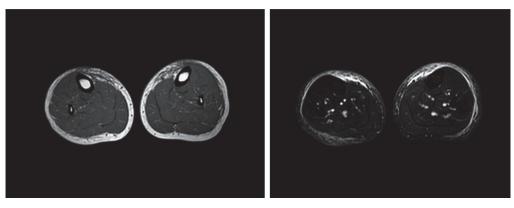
Magnetic response imaging (MRI) of lower legs. Left: T1-weight image on MRI. Right: Short tau inversion recovery images on MRI. The T1-weighted images and Short tau inversion recovery images on MRI of the lower legs showed a high signal intensity centered on the adipose tissue of the subcutaneous ventral Aspect of both lower legs.
